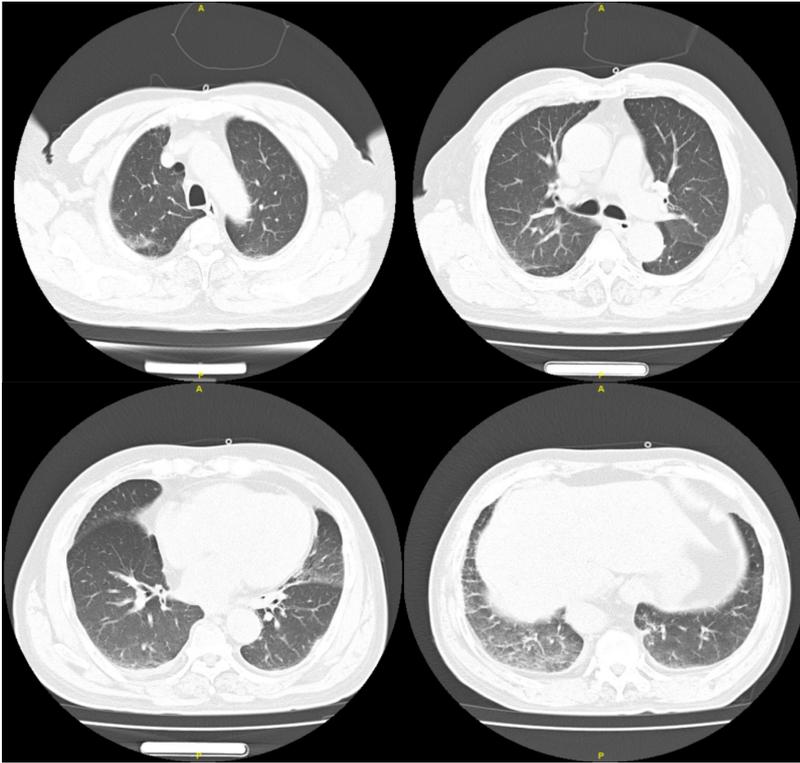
Chest computed tomography scans showing little ground glass shadow under the pleura of both lungs.
